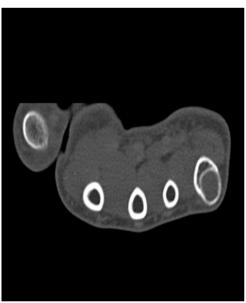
CT scan of the left hand, axial section in bone window: osteolytic lesion of the 5th metacarpal.
